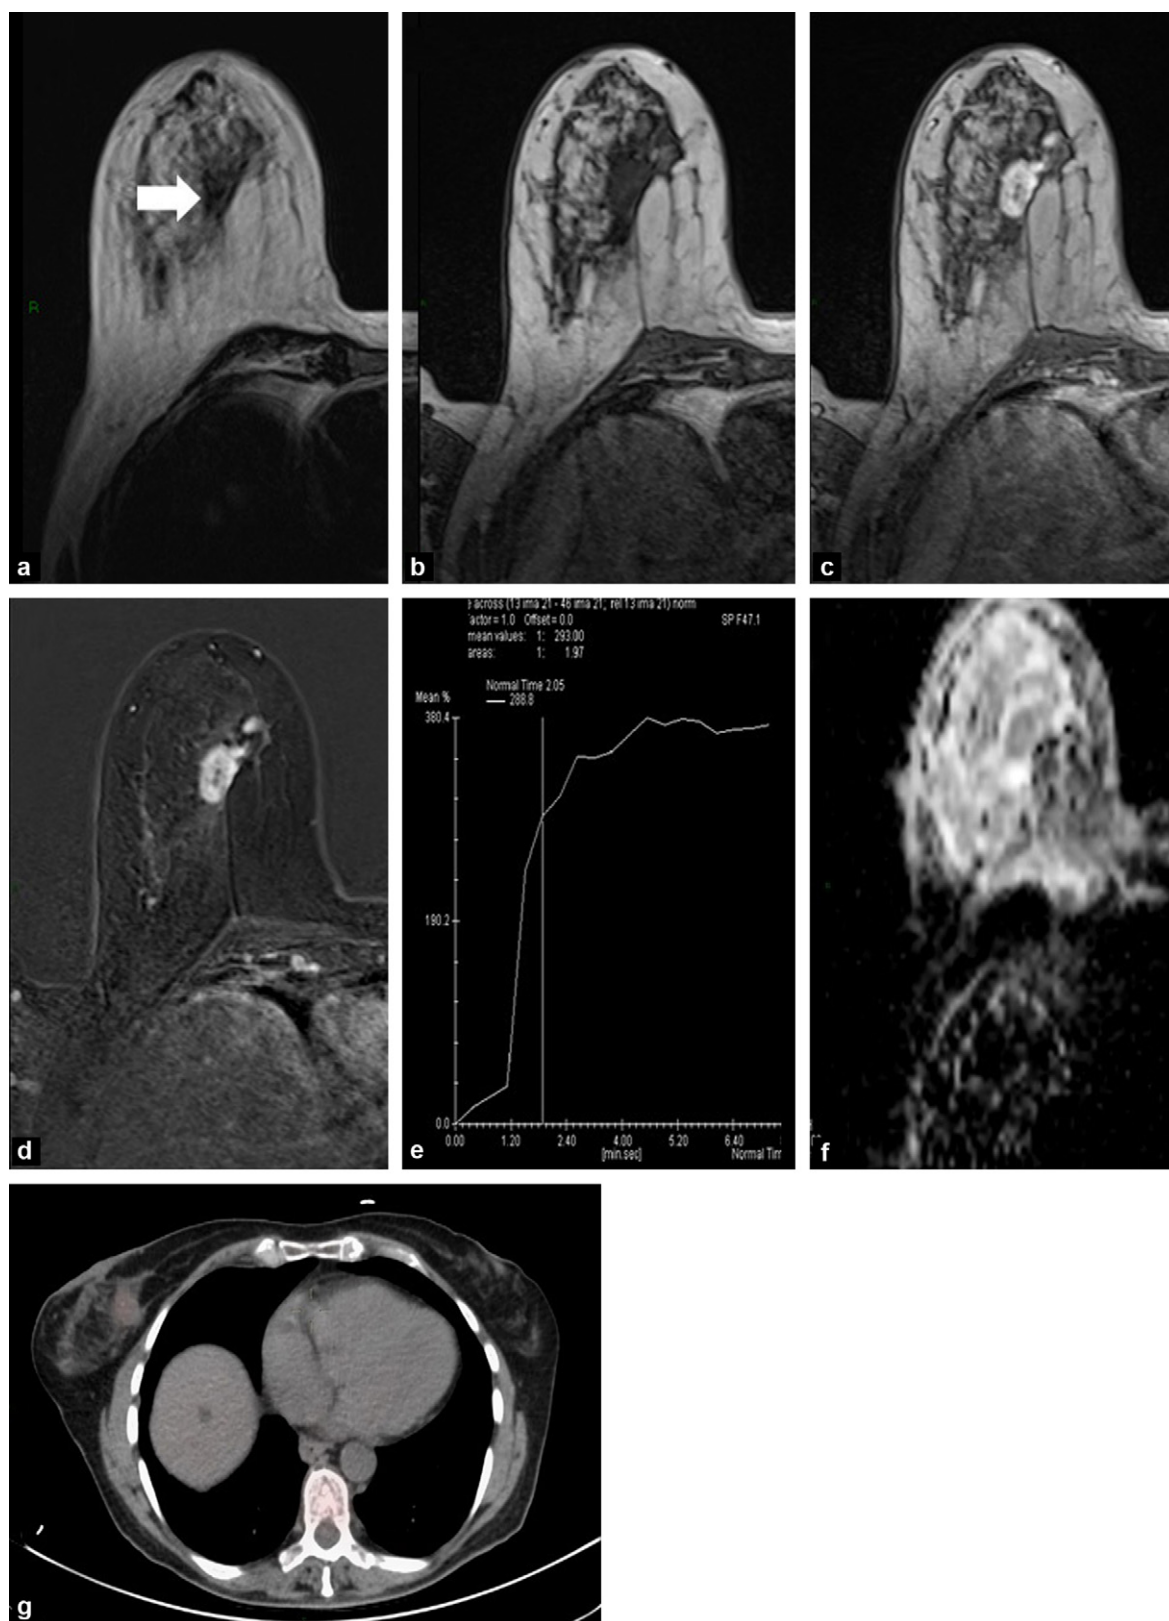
MRI and PET-CT monitoring after two courses of chemotherapy (same patient as Fig. 5). After two courses, the MRI morphological analysis shows an approx. Fifty percent reduction in volume of the mass (arrow) (a). Functional analysis shows less pejorative, intense (288% at 2 minutes) but progressive (type 1) tumoural enhancement kinetics (b, c, d, e). The diffusion sequence (f) shows an increase in the diffusion with an ADC measured at $1.5 \times 10^{-3} \text{ mm}^2/\text{s}$. In PET-CT with ^{18}F FDG (g), a clear reduction in hypermetabolism is seen in the tumour with an SUV measured as 3.9. These morphological and functional data after two courses predict a good final response.
